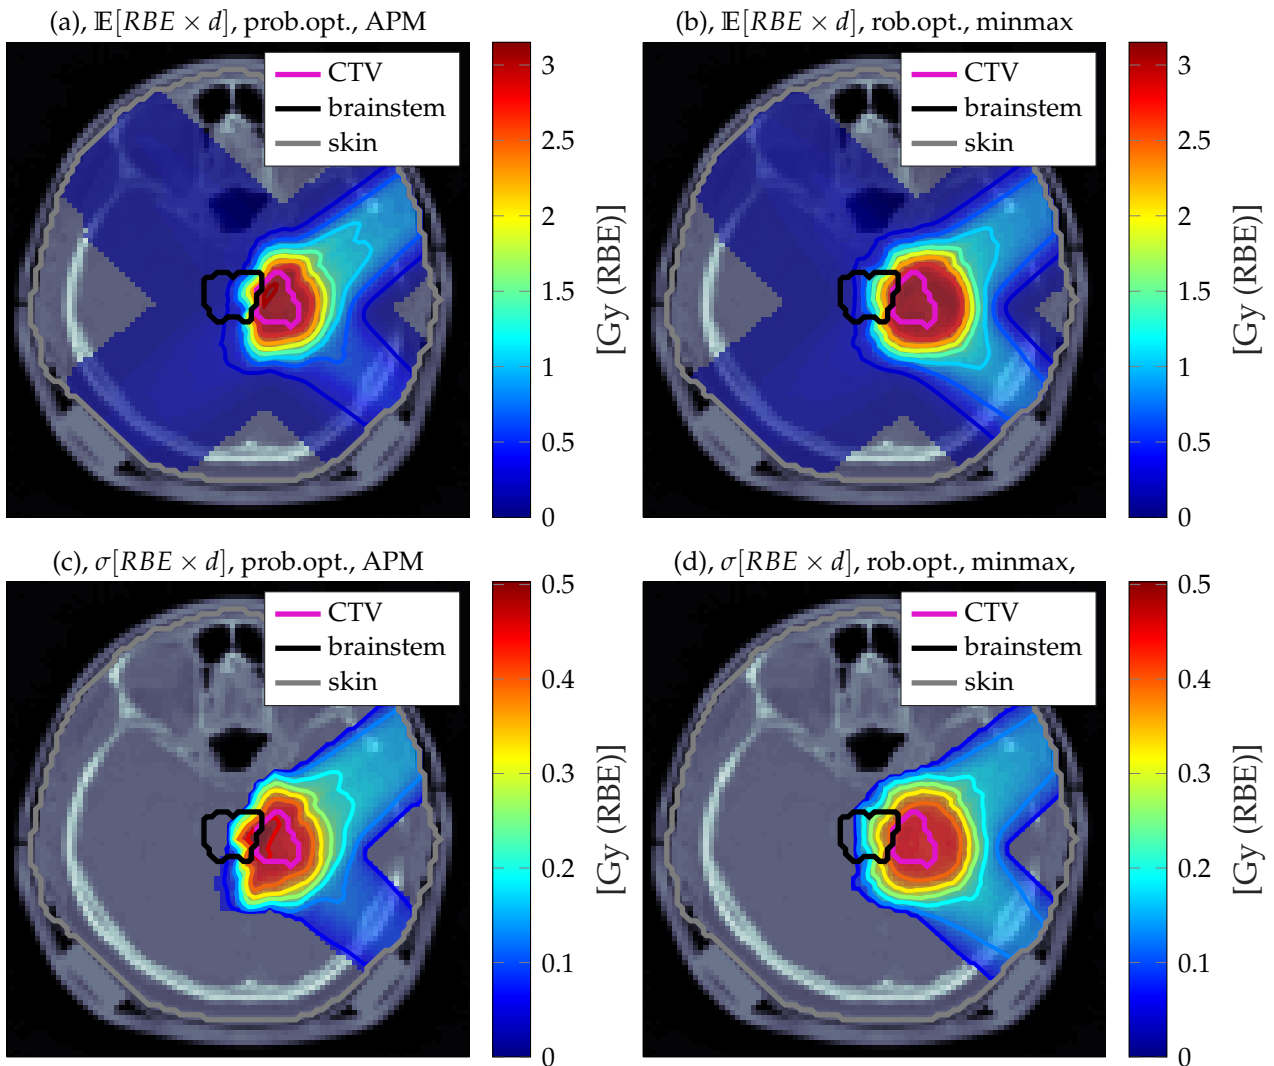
Uncertainty quantification of an intra-cranial carbon ion treatment plan using probabilistic optimization in Figures (a) and (c) and scenario based robust optimization in Figures (b) and (d). The transversal CT image is superimposed by transparent dose colorwash, solid isodose lines and solid contours. All uncertainty quantifications consider 20 fractions.
